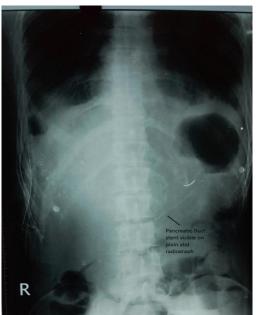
Post ERCP radiography showing reduction of pleural fluid collection and a radio-opaque pancreatic duct stent in-situ
